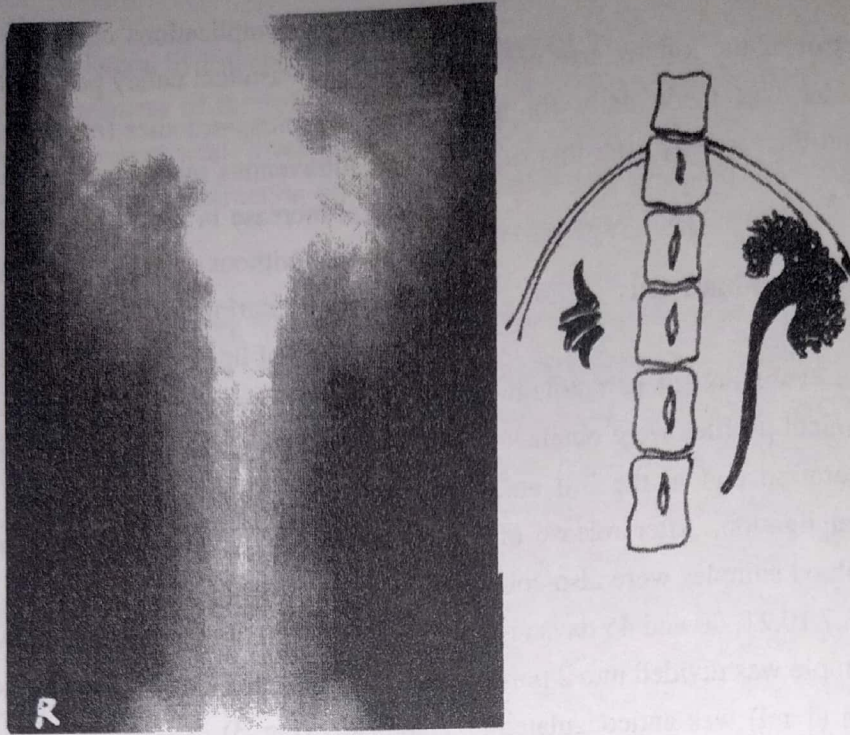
A ventrodorsal radiographical view showing the excretory pattern of urographine (2 week after removal of the ligation) note, the right kidney is not able to concentrate the dye as the left one. The right ureter is not yet perceptible.
